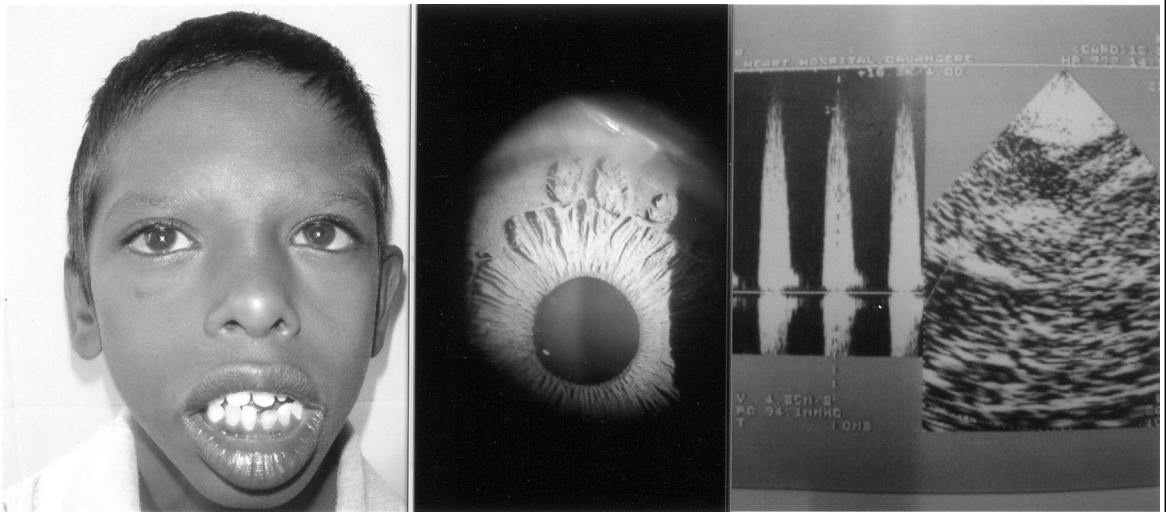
Williams syndrome, appreciate the periorbital fullness with medial eyebrow flare. Patient has prominent lips with a open mouth. Slit lamp examination revealed characteristic stellate iris pattern. Echocardiogram confirmed the diagnosis of supravulvular aortic stenosis.
